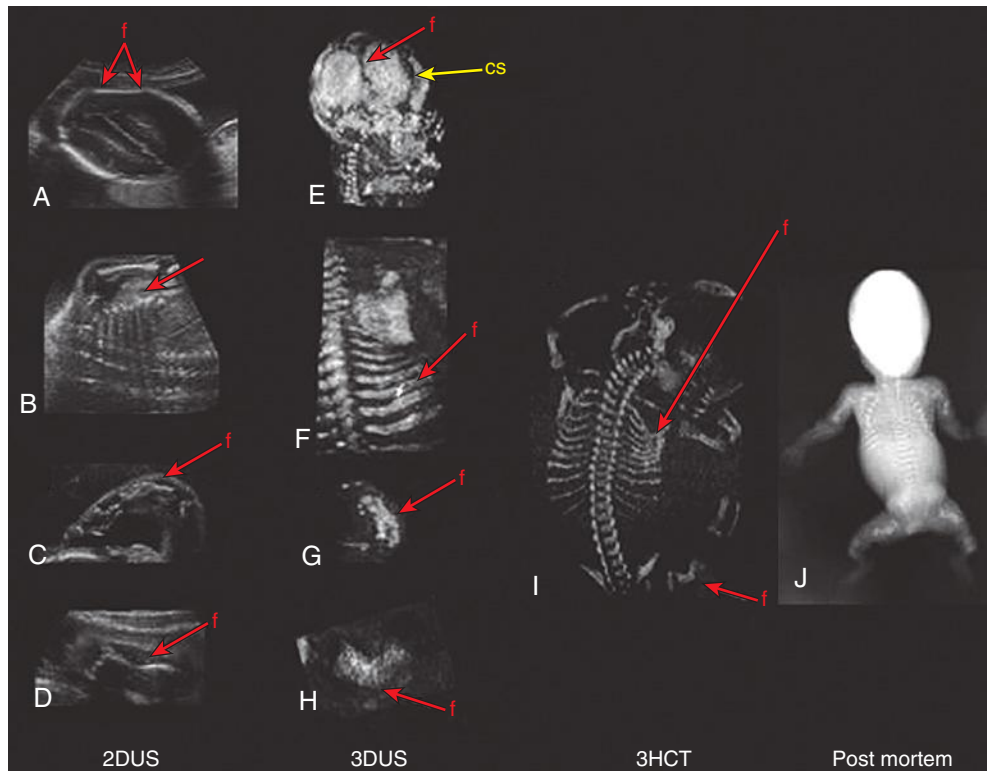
Comparison of phenotypic features of osteogenesis imperfecta by three-dimensional helical computed tomography (3HCT), three-dimensional ultrasound (3DUS) images, two-dimensional ultrasound (2DUS) images, and postmortem radiographs. A, 2DUS: transverse section of fetal head with a skull fracture (f) deformed by the transducer pressure. B, 2DUS: coronal section of fetal thorax showing irregular ribs (arrow). C, 2DUS: sagittal section of the right superior limb showing a short and bowed arm. D, 2DUS: sagittal section of fetal femur with a fracture (f). E, 3DUS image showing lateral view of fetal skull with a fracture (f) that could be differentiated from a normal coronal suture (CS) by the location and the abnormal shape depending on the transducer pressure; this was confirmed by postmortem examination. F, 3DUS-rendered bone mode demonstrating posterior view of fetal thorax showing fractured and irregular ribs (f). G, 3DUS-rendered bone mode image showing short and bowed radius and ulna. H, 3DUS-rendered bone mode image showing a fractured femur (f). I, 3HCT: posterior view of entire fetus confirming fractures (f) of ribs and femur as well as decreased mineralization of the skull. J, Postmortem radiologic examination, confirming shortening, bowing, and fracture of long bones. (From Ruano R, Molho M, Roume J, et al: Prenatal diagnosis of fetal skeletal dysplasias by combining two-dimensional and three-dimensional ultrasound and intrauterine three-dimensional helical computer tomography. *Ultrasound Obstet Gynecol* 24:134, 2004.)
